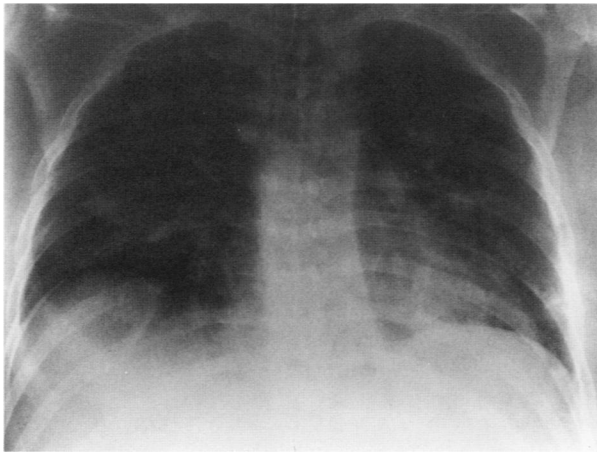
Chest radiography performed on admission demonstrated a mediastinal stripe and pleural cap.
